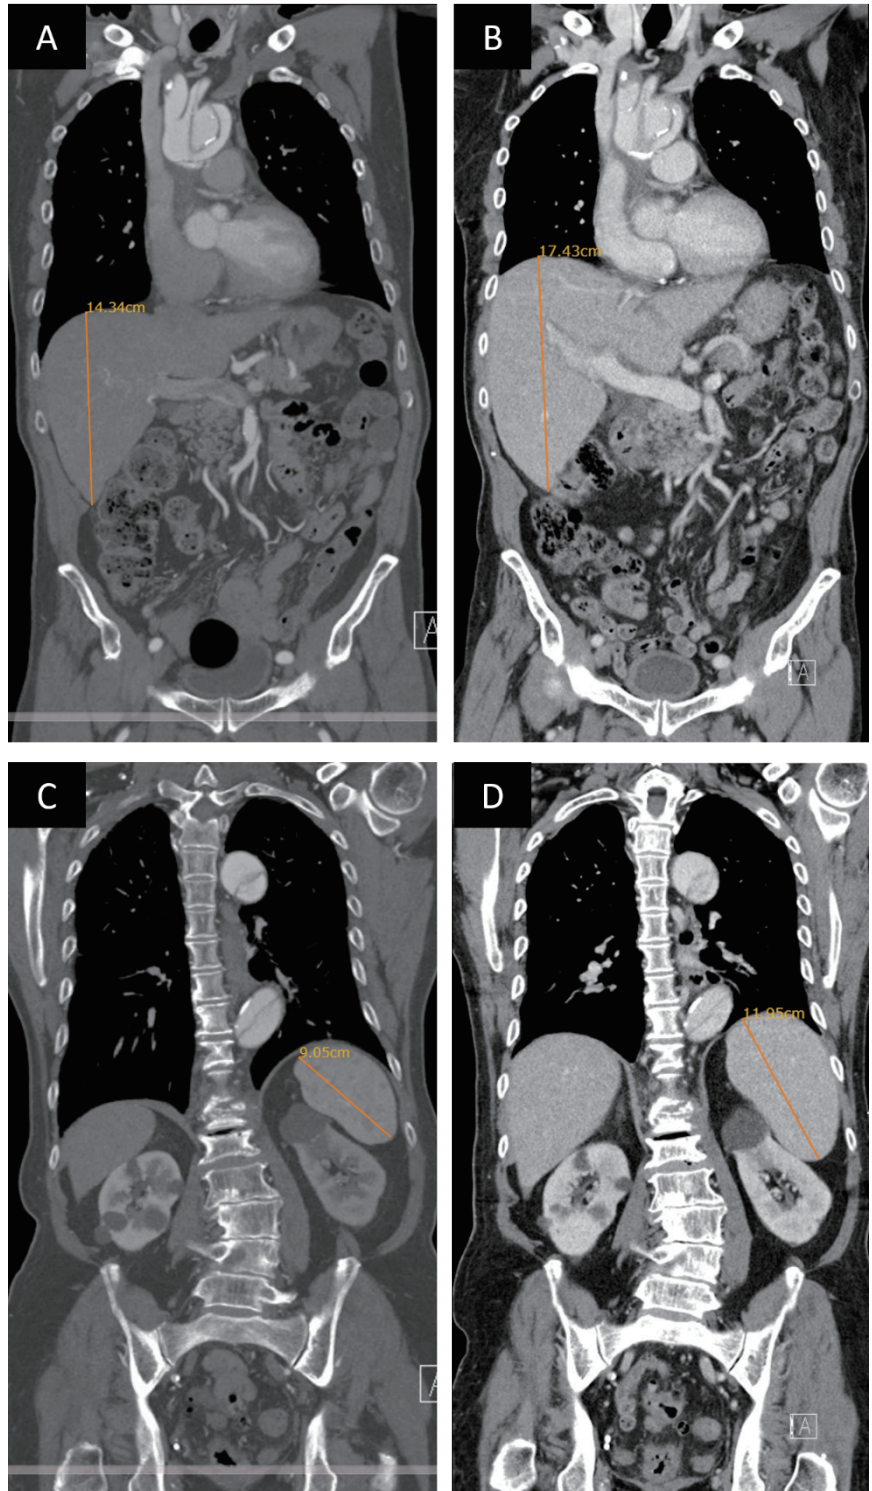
Contrast-enhanced computed tomographic images showing enlarged liver and spleen. (A) Liver (14.34 cm) 1 month prior to the ER visit. (B) Liver (17.43 cm) at the time of the ER visit. (C) Spleen (9.05 cm) 1 month prior to the ER visit. (D) Spleen (11.95 cm) at the time of the ER visit.
